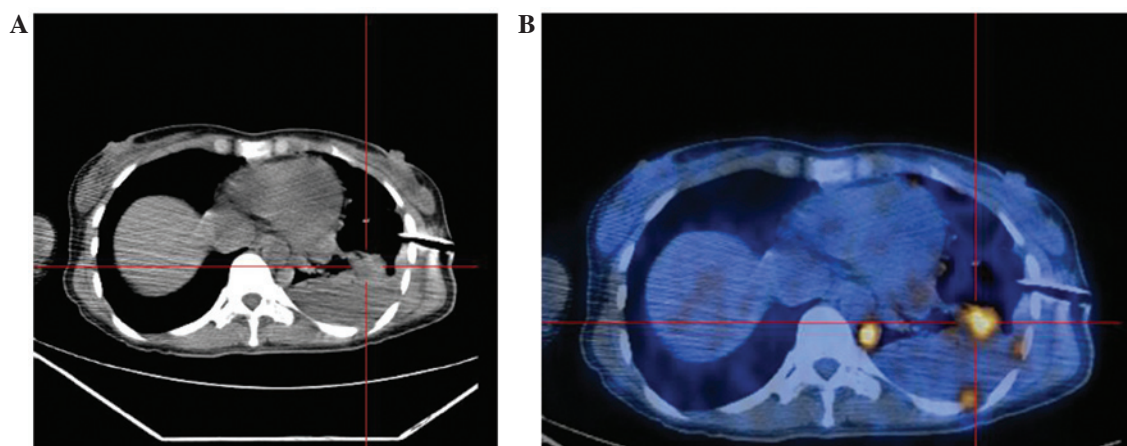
Pleural thickening protruding in the form of a nodular mass from the left thoracic wall prior to treatment is shown by the (A) computed tomography and (B) positron emission tomography scans.
